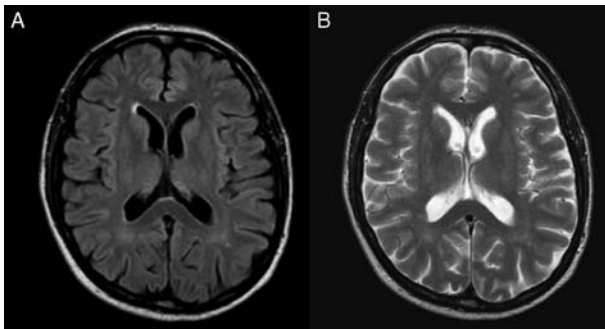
Normal findings in healthy individuals on conventional MRI: (A) axial FLAIR image, (B) axial T2-weighted image.
